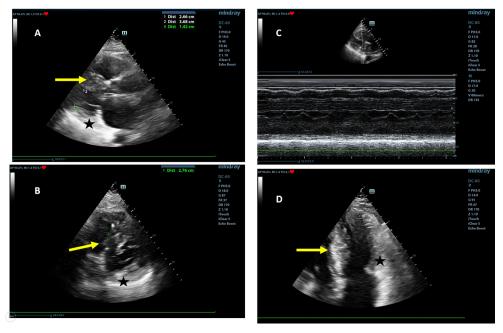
b.6. Important hypertrophy of the interventricular septum (2.66-2.76 cm, arrow), comparing with posterior, inferior and lateral LV walls (star) (images A: parasternal long axis, B: parasternal short axis, D: 4-chambers views) and lack of the SAM sign suggesting lack of obstruction (C: M-mode, parasternal long axis view)
